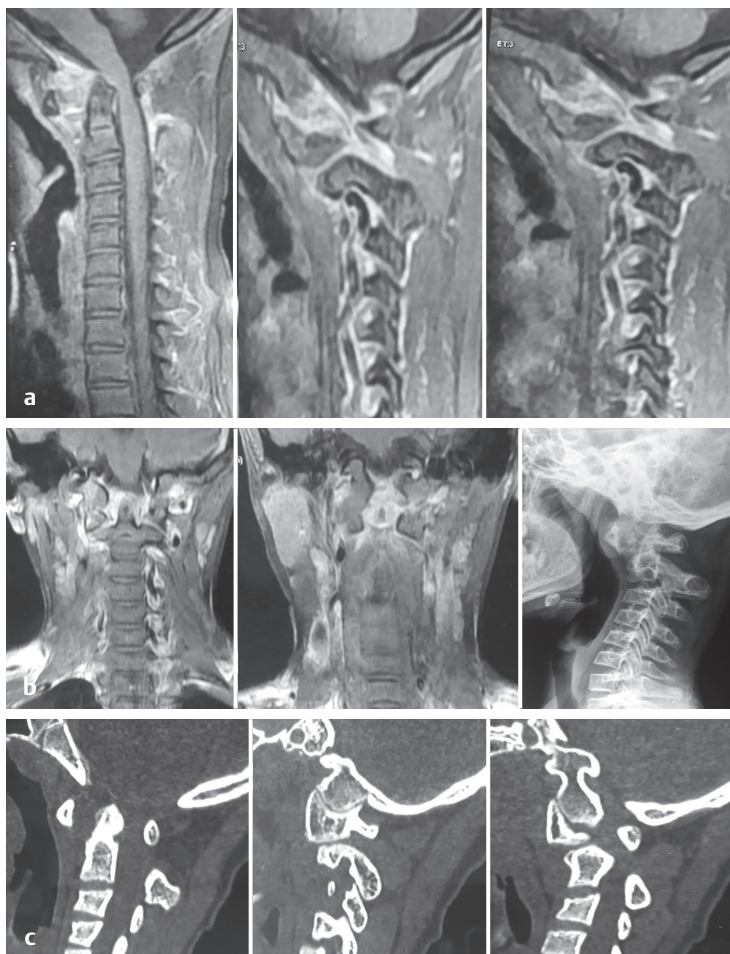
(a) Patient 2: contrast-enhanced sagittal T1-weighted MR image showing extensive granulation tissue involving the craniovertebral junction (CVJ) with atlantoaxial dislocation (AAD). (b) Patient 2: contrast-enhanced coronal MR images showing extensive tuberculous granulation tissue involving the C1–C2 facet joints and the paravertebral ligamentous and muscle planes; the lateral radiograph of the craniovertebral junction showing AAD with canal compromise. (c) Patient 2: sagittal CT reconstructed images showing AAD with a stable right C1–C2 facet joint and a displaced left C1–C2 joint.
